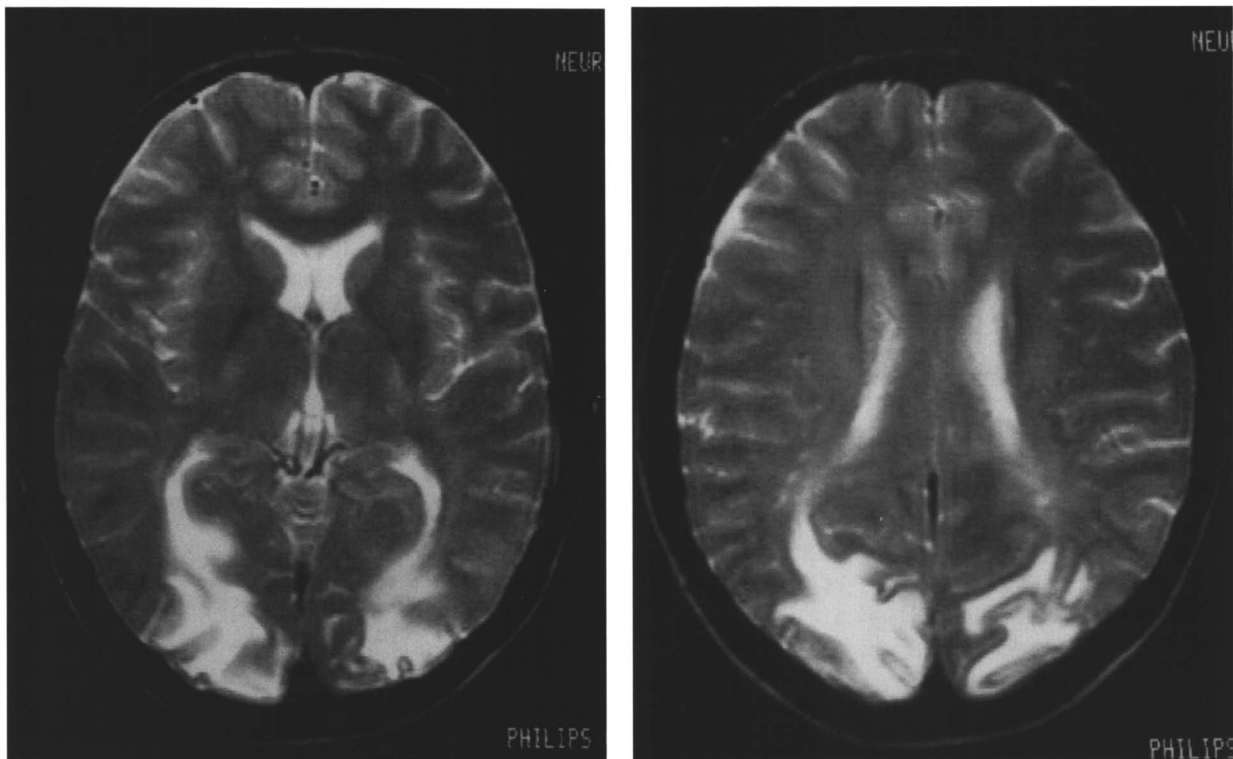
T₂-weighted axial magnetic resonance images in Patient 1. Large confluent areas of signal hyperdensities are present in the occipital cortex, including the calcarine cortex, and in the adjacent white matter.
